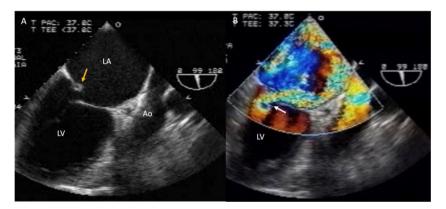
Papillary muscle rupture (A) 99° transesophageal echocardiogram with a rupture of the posteromedial papillary muscle (orange arrow). (B) Color Doppler shows torrential mitral regurgitation (white arrow). Abbreviations: LA: left atrium, LV: left ventricle, Ao: Aorta.
